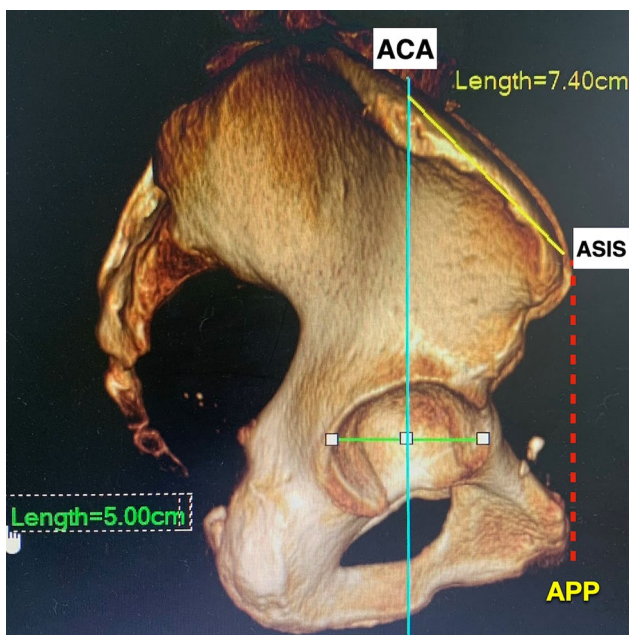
The 3D-CT pelvic image aligned to the anterior pelvic plane, with a transverse diameter line calibrated to the cup size. A vertical line through the diameter's center represented the acetabular center axis (ACA), and the ACA-to-ASIS distance was measured
